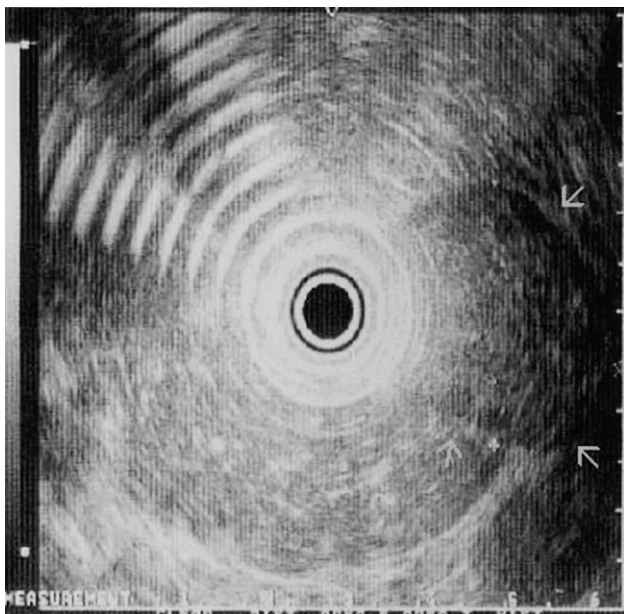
Endoscopic ultrasound imaging defined a 35 × 50 mm ovoid image with an isohypoechoic structure (arrows) protruding from the tail of the pancreas.
